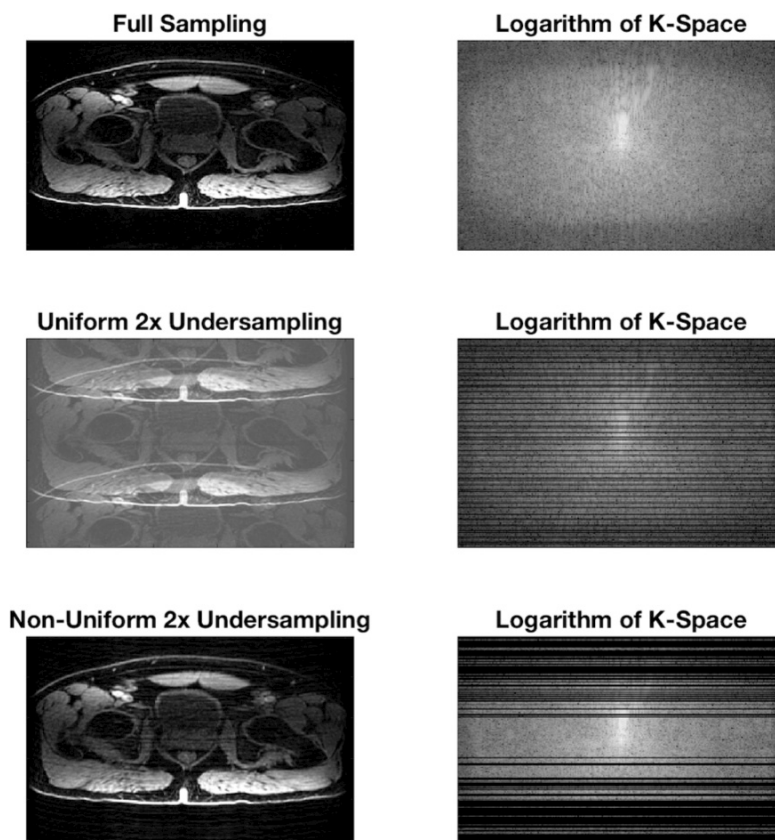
Uniform and pseudo-random undersampling of a pelvic MRI image, both retaining 50% of the original k-space data. While uniform undersampling results in coherent aliasing, pseudo-random undersampling creates noise-like incoherent aliasing artifacts below which the original image is easily visible. Pseudo-random sampling can be tailored, as in this example, to concentrate k-space sampling in regions that carry more image contrast (i.e. low spatial frequencies).
